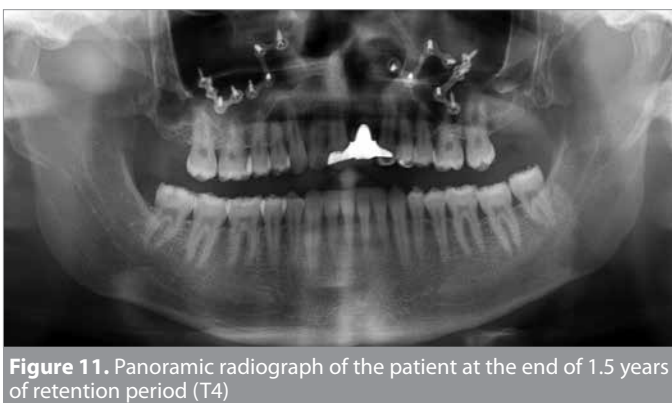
Panoramic radiograph of the patient at the end of 1.5 years of retention period (T4)
